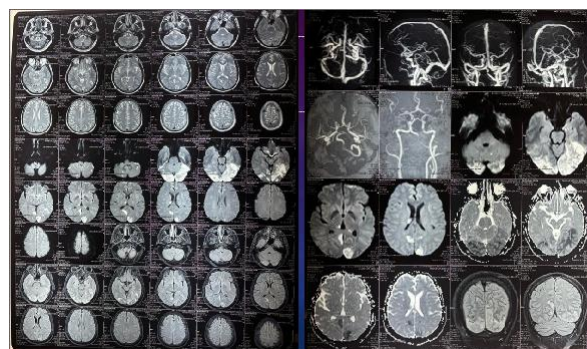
MRI Brain — T2/FLAIR and MRA sequences (axial). Left panel: multiple axial T2-weighted and FLAIR sequences demonstrating bilateral occipital, right thalamic, and bilateral cerebellar hyperintense signal corresponding to acute posterior circulation infarcts. Right panel: MR angiography (MRA) showing cerebrovascular objects.
